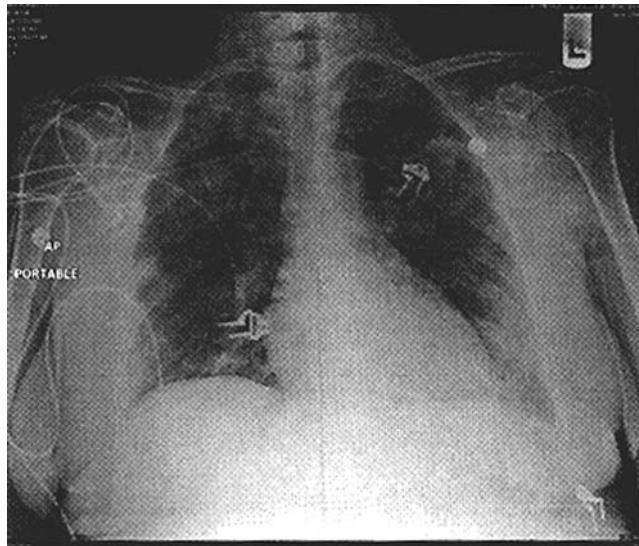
Chest radiograph performed on day 4 of hospitalization demonstrating a non-cardiogenic pulmonary edema during an acute episode of shortness of breath
